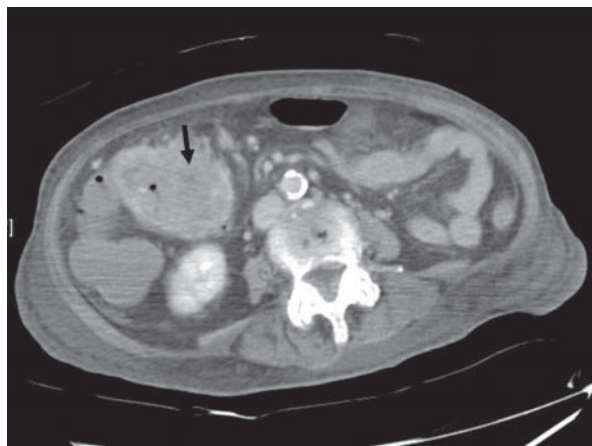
The computed tomography of the abdomen and pelvis revealed a tumor in transverse colon (arrow).
